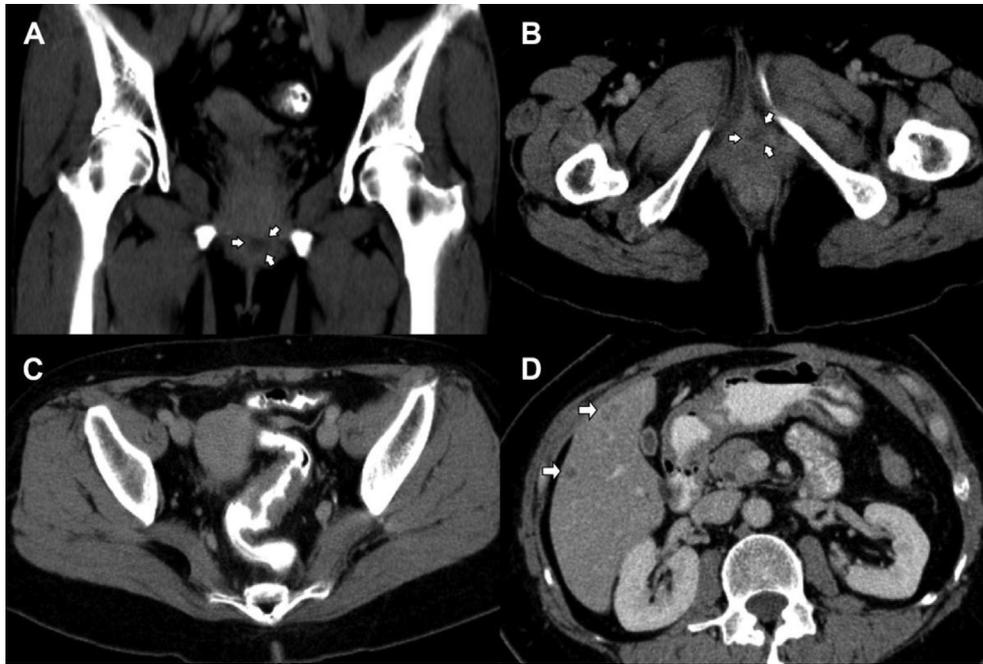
CT scan images for the lesions. (A) (B) Pelvic computed tomography (CT) revealing an ill-defined soft tissue mass (arrows), compatible with the initial diagnosis of Bartholin duct ADC. (C) A stricture lesion in the sigmoid colon. (D) Multiple nodular lesions (arrows) in random distribution in the liver suggesting metastasis.
